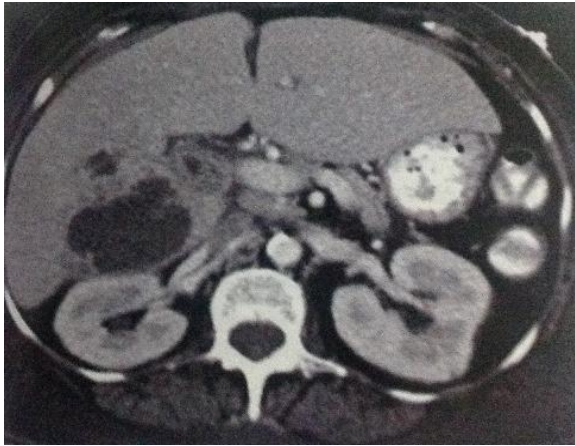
Amebic liver abscess, the CT scan reveals a large, round measuring 6cm.
